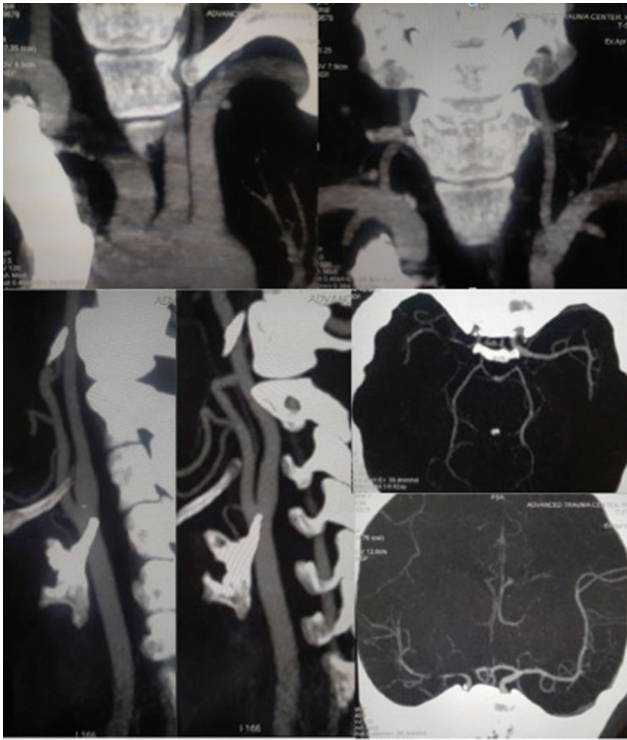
Computed tomography (CT) angiography depiction of the entire cervicocranial arterial system during stroke evaluation. Note thrombus in the right middle cerebral artery (MCA).
